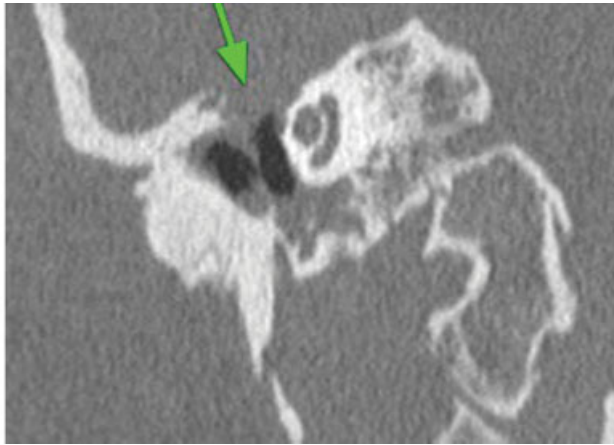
Right-sided middle fossa skull base dehiscence (arrow) visualized on coronal CT of the right temporal bone.
